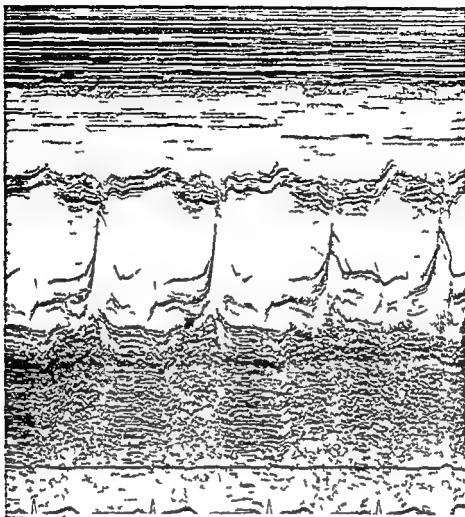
Echocardiogram recorded on patient No 9 The arrow indicates late systolic prolapse of the posterior leaflet of the mitral valve
